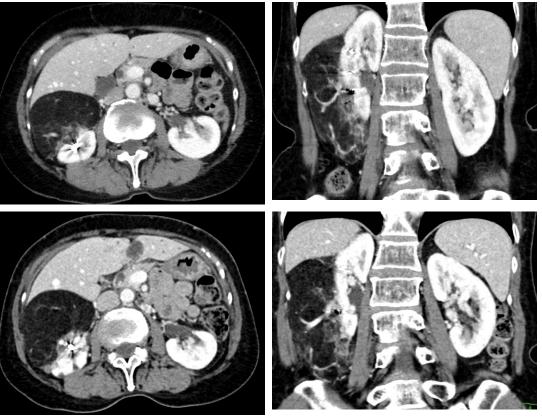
Axial and coronal sections of CT kidneys
